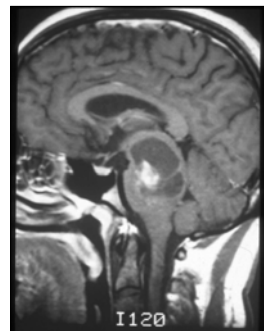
Sagittal T1-weighted MRI scan demonstrating a cystic, enhancing lesion in the pons and midbrain.
